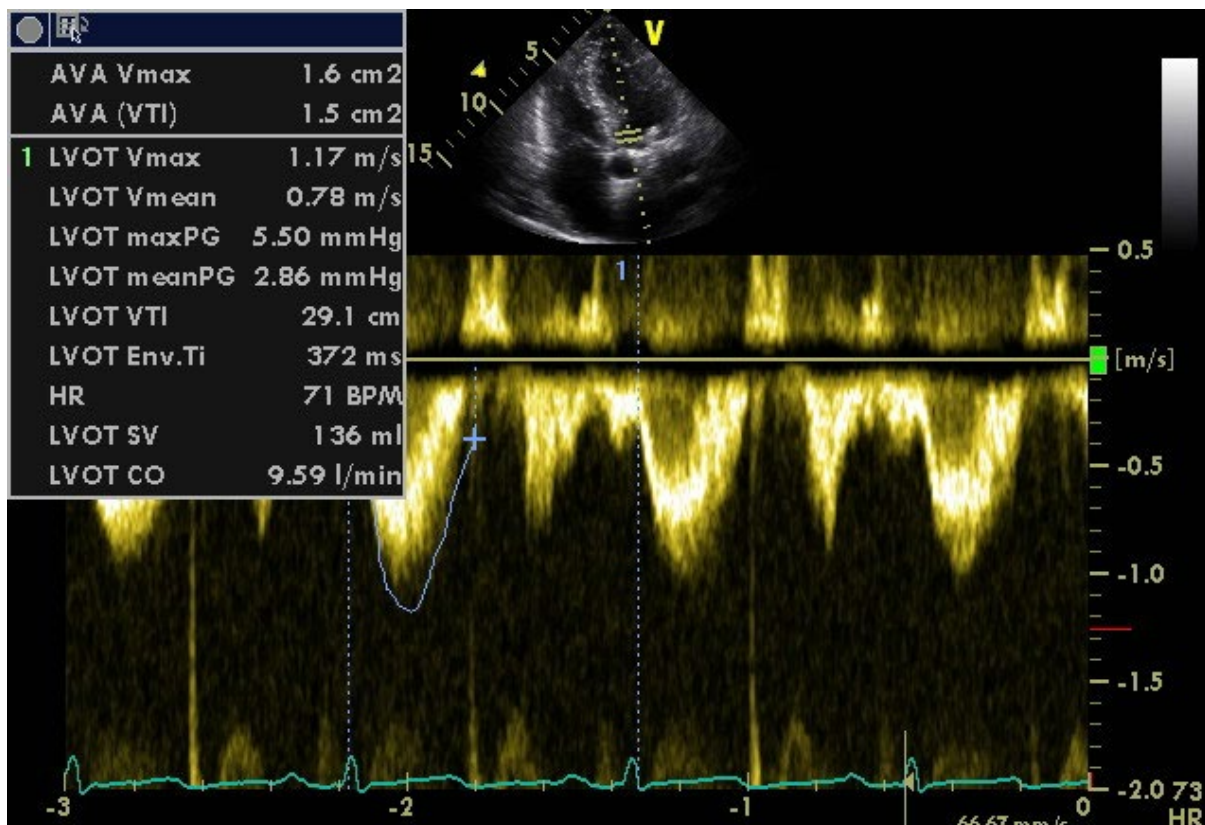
Measurement of LVOT velocity in apical five chamber view. Adapted from Hagendorff et al. (2020).^[249]
